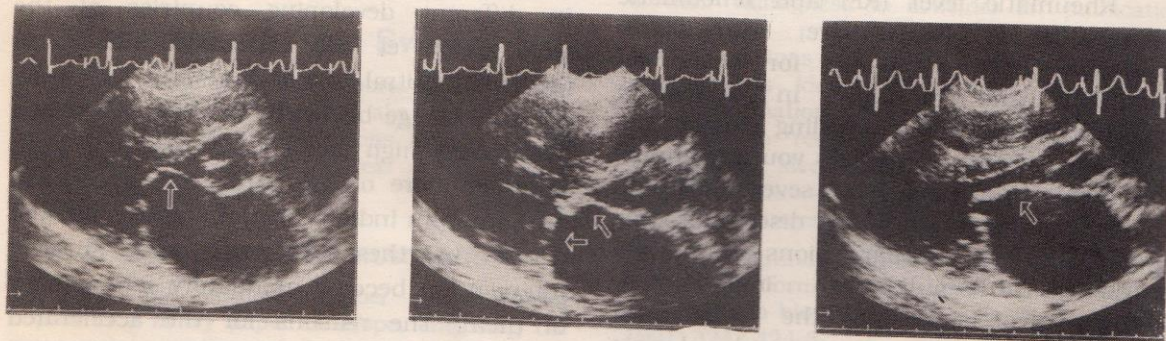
Long axis two-dimensional echocardiograms of the left ventricle in diastole showing the mitral valve and subvalvular apparatus from three patients with varying degree of dome formation of AML and severity of subvalvular lesions. Left panel : Little thickening of the leaflets with severe dome formation of AML demonstrating its pliability. The subvalvular apparatus is not significantly diseased. Middle panel : The mitral leaflets are thickened to a greater extent with moderate dome formation of AML indicating some rigidity. The chordae tendineae are thickened as well. Right panel : The leaflets are markedly thickened and rigid with minimal dome formation of AML. The submitral apparatus is also severely involved, with marked thickening and fusion of chordae.
